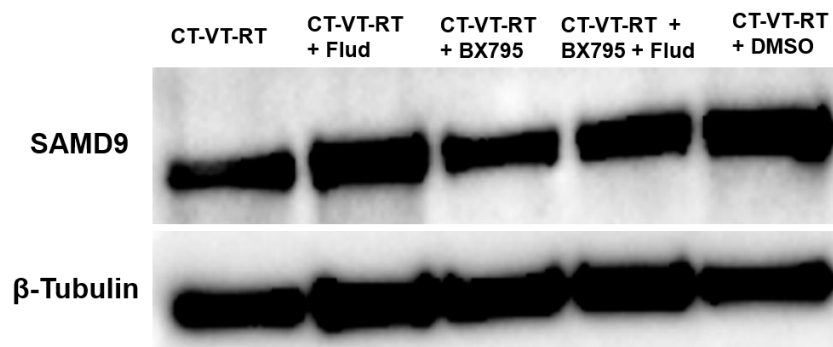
SAMD9 expression remains unchanged upon small molecule inhibition. Immunoblots reveals similar levels of SAMD9 protein (upper panel) post CT-VT-RT and in combination with inhibitors. β -tubulin served as loading control (lower panel).
